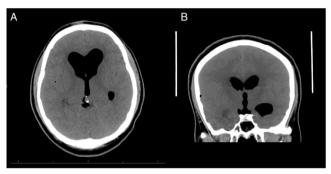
(A) Axial and (B) coronal CT images showing extensive tension pneumoventricle.
